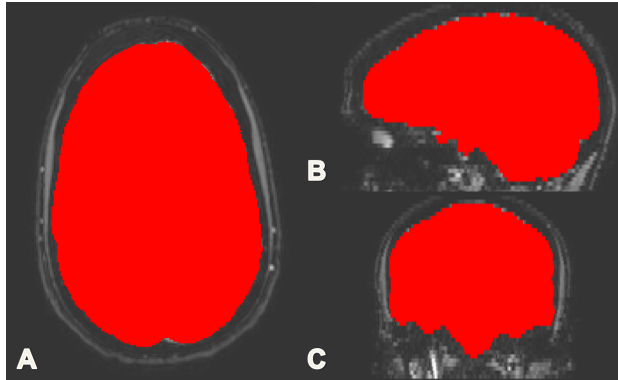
The ICV derived from the CSF MRI sequence. Example of the ICV in an axial (A), sagittal (B) and coronal (C) slice. The mask resulting from the BET application to the CSF data is shown in red. The raw CSF data is shown in gray-scale in the background.
